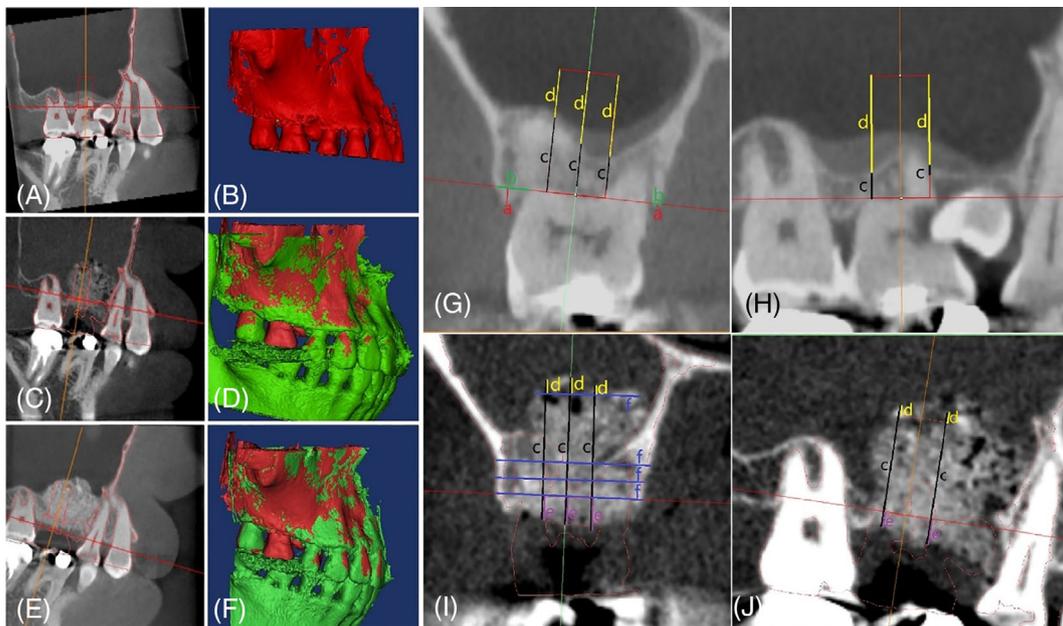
Description of CBCT registration and alveolar ridge measurements (A–J) (Case 5). (A, B) Images of a virtually placed implant and the maxilla on a pre-extraction CBCT scan were created and exported as an STL file. (C, D) Images of the virtual implant and maxilla were superimposed onto T1 CBCT data. (E, F) Images of the virtual implant and upper jaw were superimposed onto T2 CBCT data. Preoperative (T0) and postoperative (T1) alveolar ridge parameters were measured with respect to the virtual implant on the coronal (G, I) and sagittal (H, J) sections: socket bone plate height above the virtual implant platform (a); socket bone plate thickness (b); sinus floor height (c); implant protrusion height (d); crestal bone height above the virtual implant platform (e); and alveolar ridge/bone graft thickness (f) at 0, 2, 4, and 10 mm below the virtual platform
